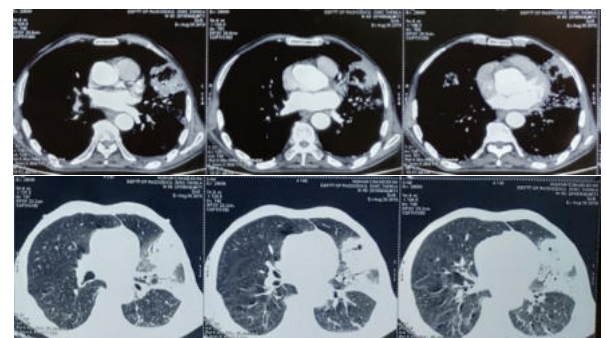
Large heterogeneously enhancing mass in anterior and apico-posterior segment of left upper lobe measures about 8X6.9X 6cm in (AP X trans X CC). The mass is encasing left MPA and causing left upper bronchus cut off. Laterally reaching up to the lateral pleural surface . Small subcentimetric sized pleural based nodules and adjacent pleural thickening is also seen in left upper lobe contiguous with this mass representing metastatic deposits, Small pleural based nodules are also seen in right middle lobe along costal pleura. The largest of these nodules measures 1.2 X1cm .Few enlarged and small subcentimetric sized pretracheal ,subcarinal lymph nodes.Chest radiograph shows round opacity in left upper and mid zone silhouetting with thoracic cage and left hilum.Appearance of mass on ultrasound chest .
